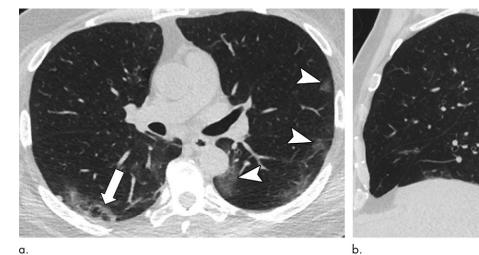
Images in a 57-year-old man with COVID-19 presenting with 4 days of cough. (a) Axial and (b) sagittal unenhanced thinsection chest CT images show bilateral ground-glass opacities in peripheral distribution in left lung, some with rounded morphologic presentation (arrowheads). There are also arcadelike opacities in subpleural right lower lobe (arrows), indicative of perilobular pattern of disease.
